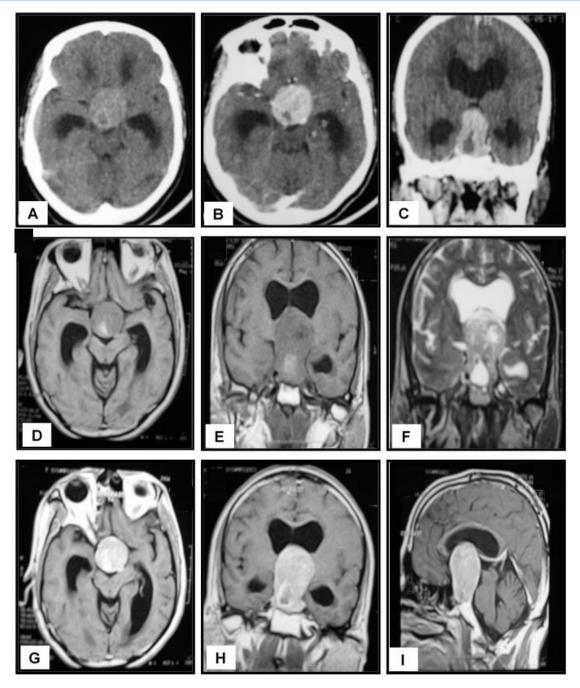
Pituitary macroadenoma. A 47-year-old female patient presented with diminution of vision and headache. CT Examination: (A) Axial cuts show a well-defined sellar lesion with suprasellar extension compressing upon the third ventricle with dilatation of frontal horns of both lateral ventricles. The lesion is isodense with a small cystic area seen inside. (B) and (C) Post-contrast axial and coronal cuts of the same patient show intense homogeneous enhancement of lesion sparing cystic area. MRI examination: (D) an (E) Axial and coronal T1-W1 of the same patient shows a well-defined isointense sellar Space occupying lesion with suprasellar extension compressing upon optic chiasm. The lesion showed a small area of hyperintensity. (F) Coronal T2-W1 of the same patient shows a heterogeneous intensity of the lesion. The small hyperintense area is seen at T1WI also appeared hyperintense at T2WI, denoting subacute hematoma. (G), (H), and (I) Post-contrast axial, coronal and sagittal T1-W1 of the same patient show a heterogeneous enhancement of the lesion.
